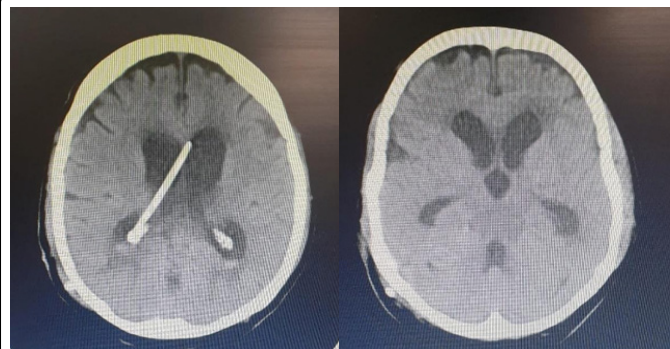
CT shows dilatation of ventricles with ballooning of 3rd ventricle.
